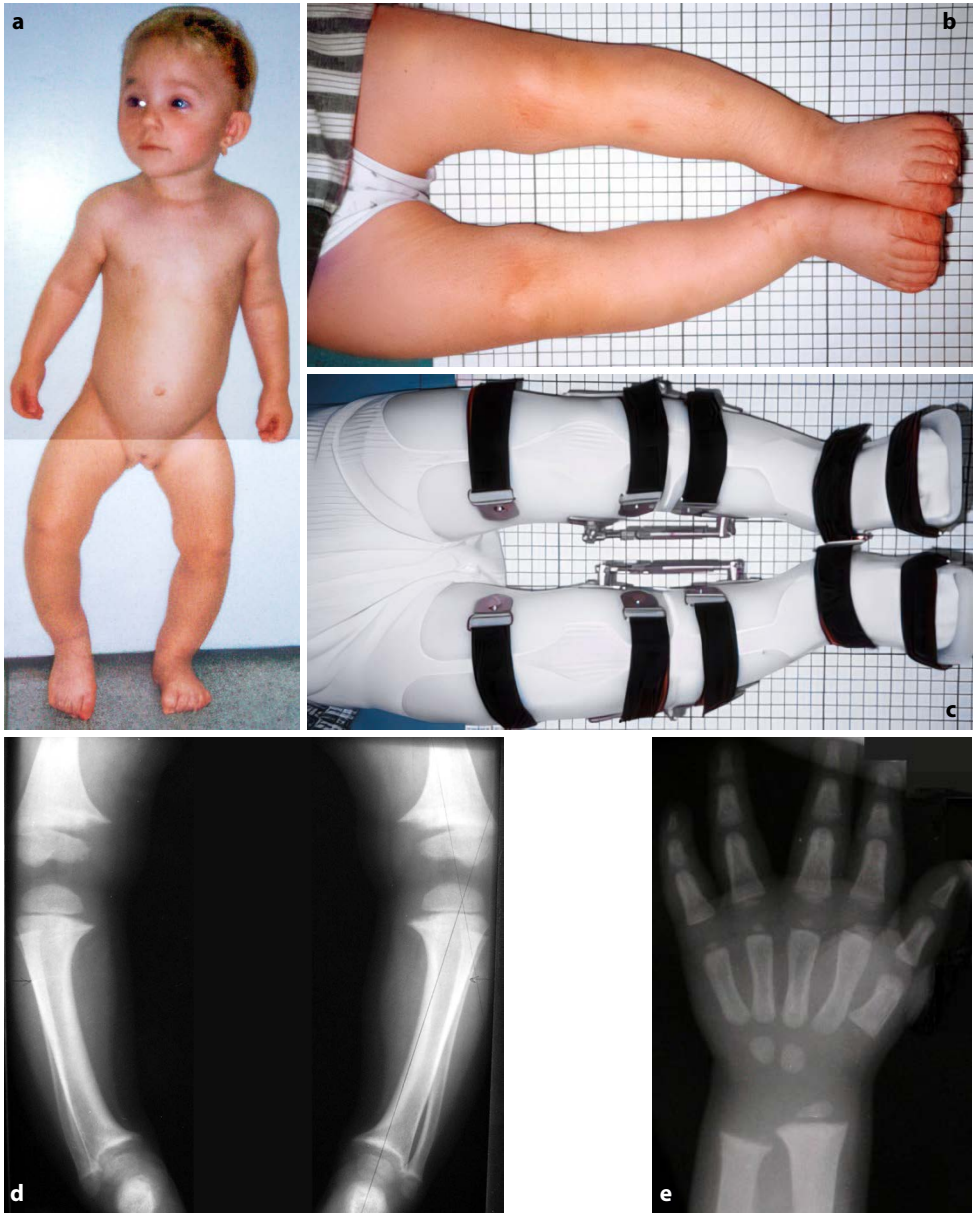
a. phenotype of a girl at 2 years with varusity of the knees and shanks; b. intercondylar distance in lying 5 cm; c. orthoses of lower limbs with bending pre-stressing; correction of varusity is at the level of the proximal tibia; d. X-rays of shanks and left hand at 20 months. Tibio-femoral angle is bilaterally about -28° ; flaring of metaphyses at knee joint areas, varusity and cupping of the distal tibia metaphyses; overgrowth of fibula bilaterally; e. rachitic changes on the hand. The cortical thinning of the metacarpals and phalanges, slightly cupped distal metaphysis of ulna and radius.
